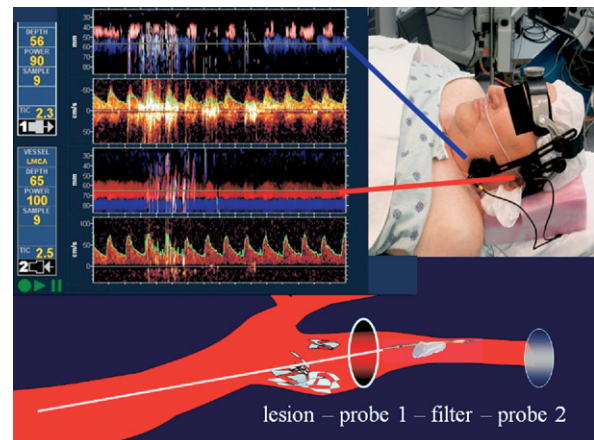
Dual probe transcranial Doppler monitor setup as seen on the patient and as it relates to the carotid artery embolic protection device.
